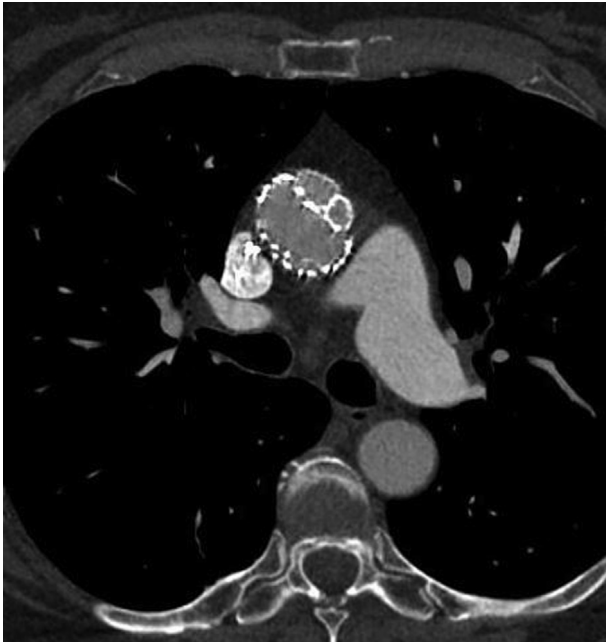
Postoperative computed tomography angiogram indicating zone 0-5 chimney stent graft orientation.
